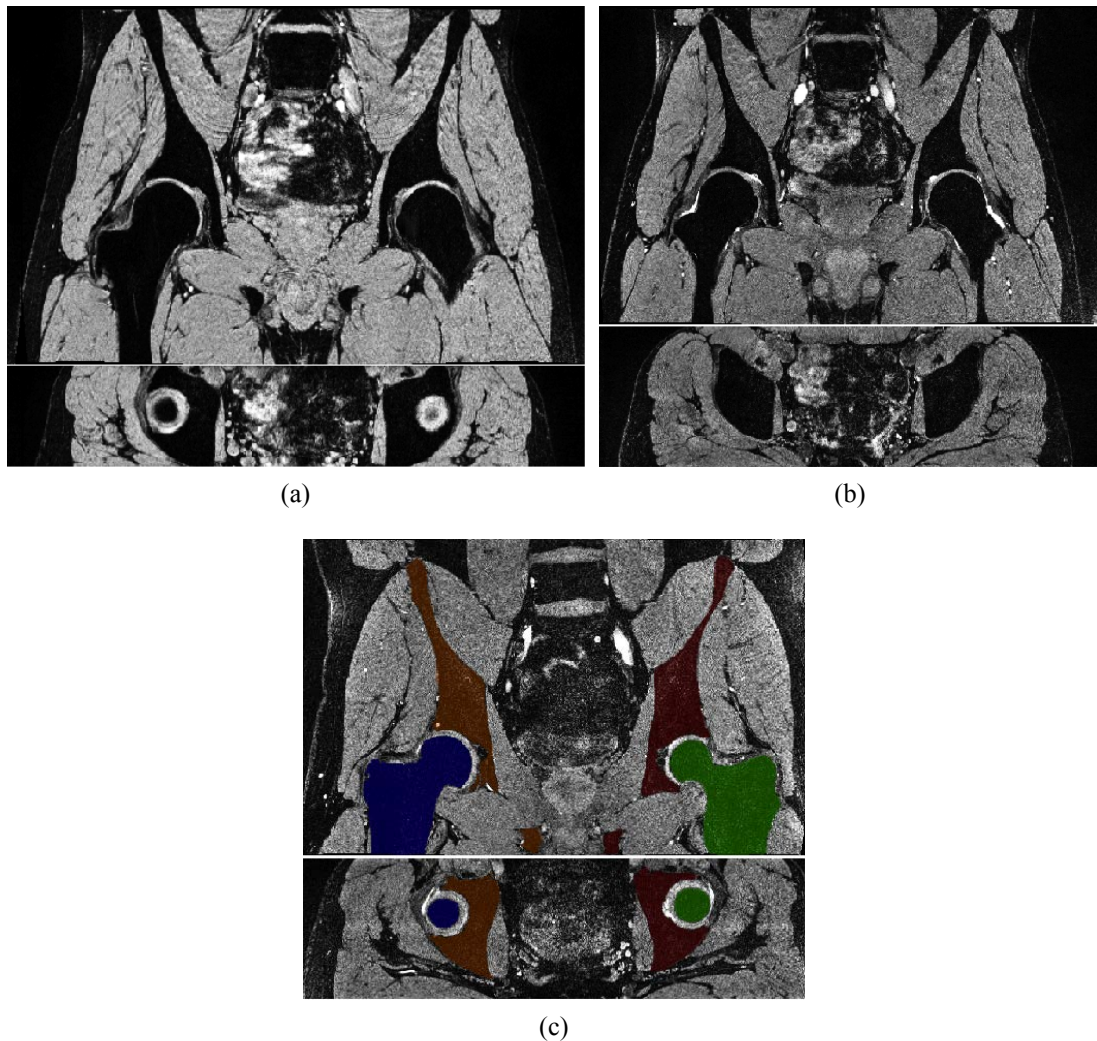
Example (top) coronal and (bottom) axial slices of MR images with multiple sequences as well as an example of manual segmentations of the proximal femur (blue, green) and innominate (brown, red) bone elements: (a) MEDIC; (b) DESS; (c) manual labels overlaying on a DESS image.
